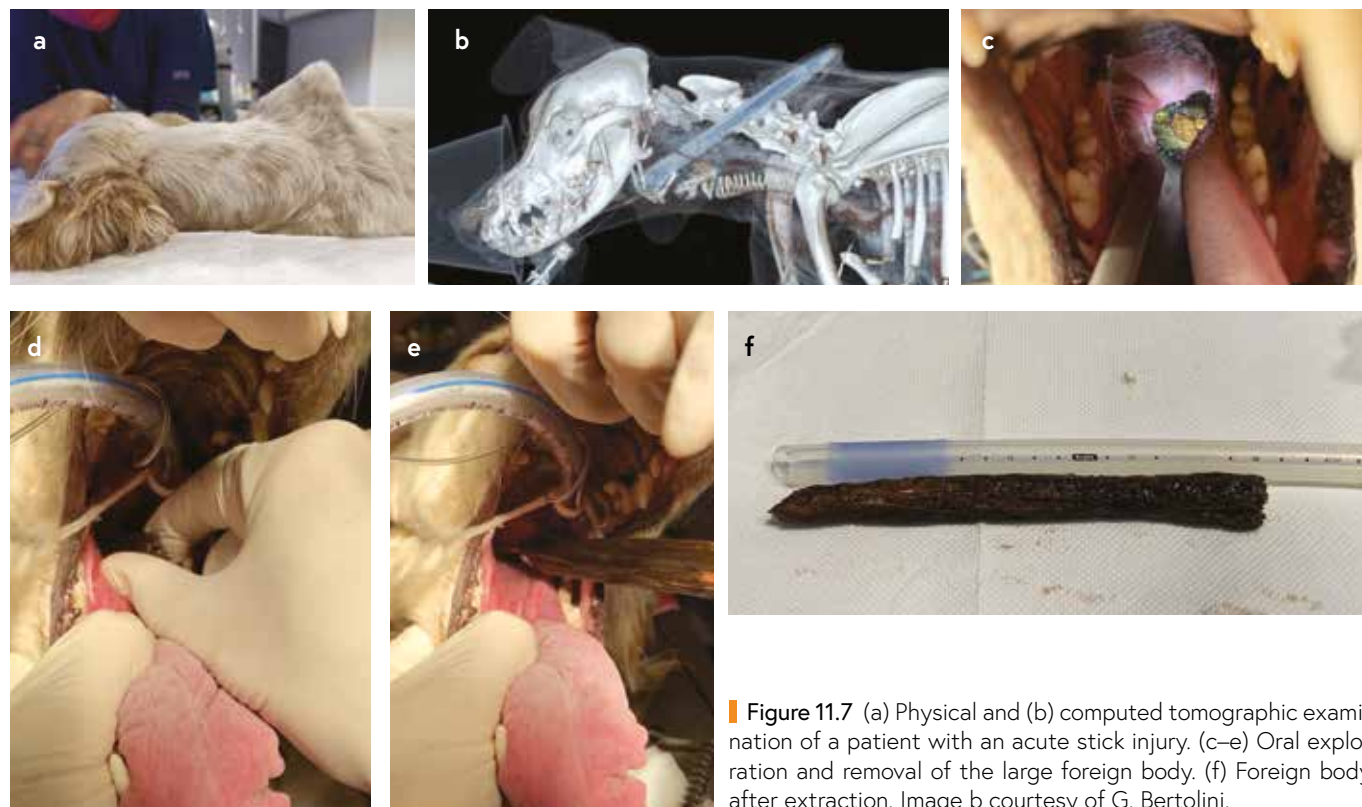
(a) Physical and (b) computed tomographic examination of a patient with an acute stick injury. (c–e) Oral exploration and removal of the large foreign body. (f) Foreign body after extraction. Image b courtesy of G. Bertolini.
